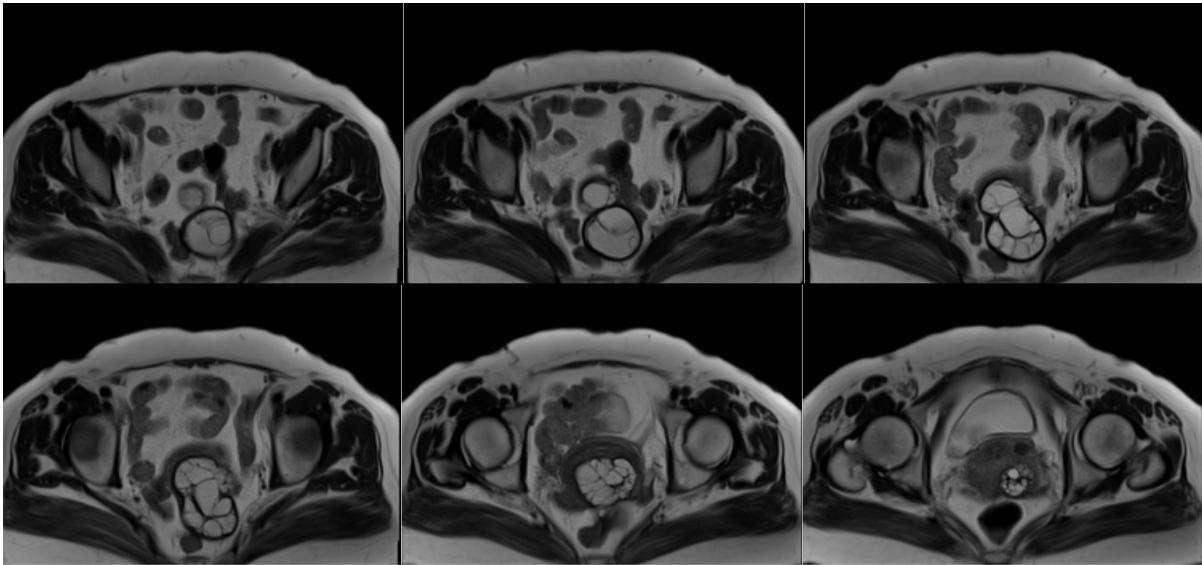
T2-weighted MR imaging reveals hyperintense multiseptal cystic development.
